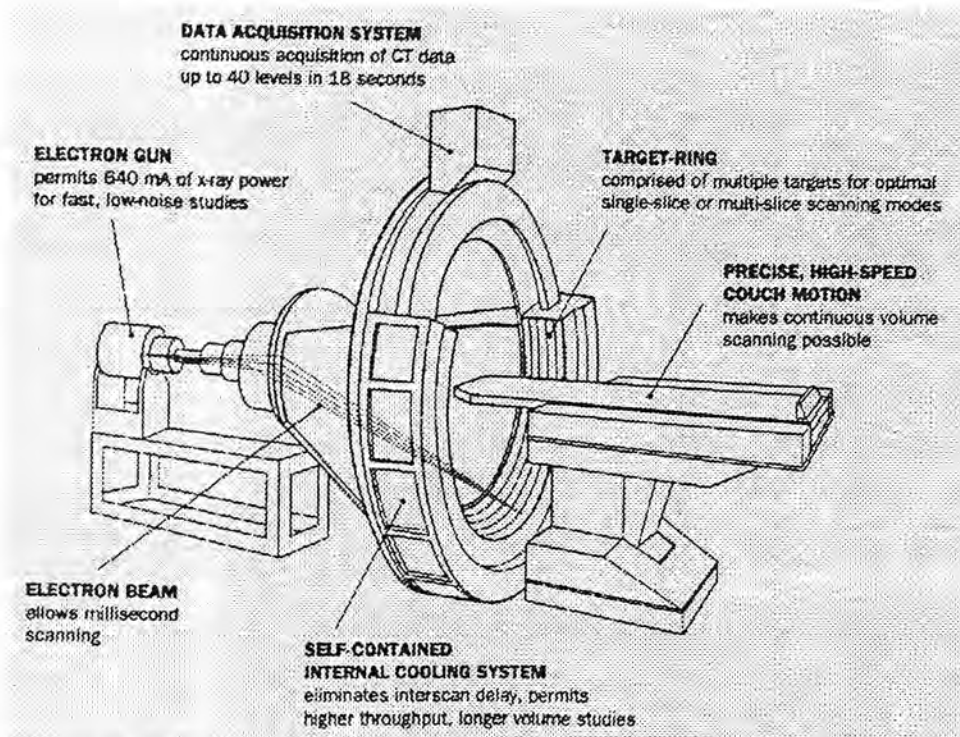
Major components of the Ultrafast CT scanner (Imatron) (Webb 1988).
